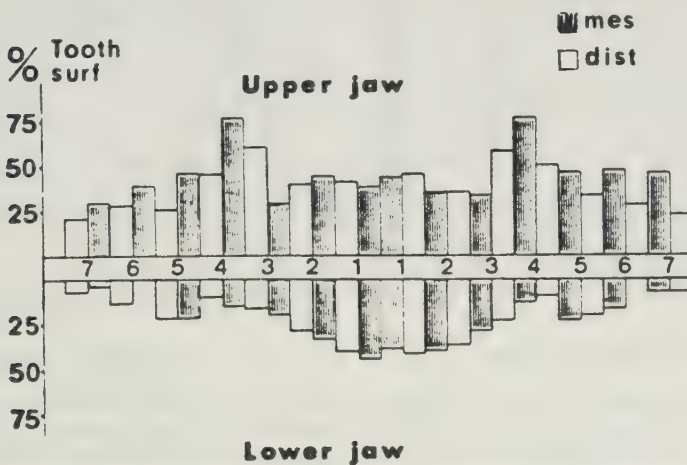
The percentual distribution of non-measurable tooth-surfaces in bone score measurements in panoramic radiographs (PAN).
